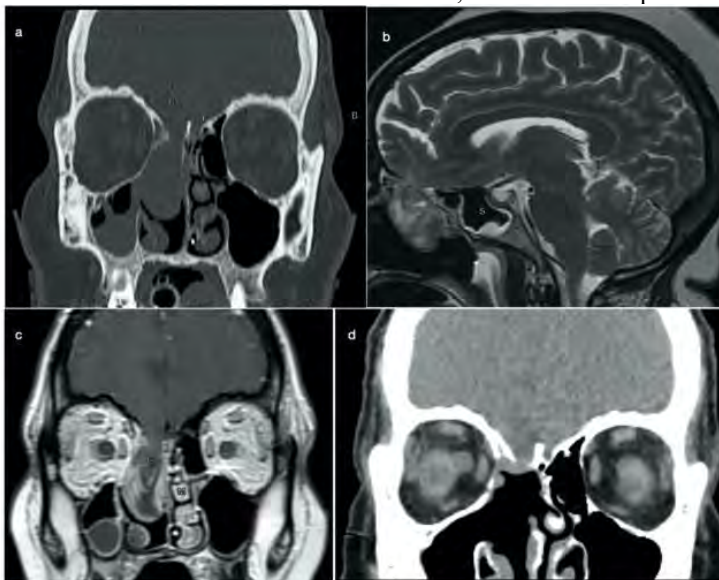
CT bone (a) demonstrating an erosion of the skull base, specifically the region of the cribriform plate along the floor of the anterior cranial fossa, as well as a severely downslipping olfactory plate (C) and a Type 3 olfactory fossa by the Keros classification; both congenital variants that may predispose to bony defects. T2 weighted MRI (b) demonstrates herniation of brain tissue through a defect in the floor of the anterior cranial fossa into the nasal cavity. T1 weighted MRI post-contrast (c) demonstrate the encephalocele with surrounding enhancing dura and mucosa; f also showing the encephalocele obstructing the middle meatus. Postoperative CT bone and sinus (d) shows the intruding tissue resected and reduced, supported by a Durepair inlay.
